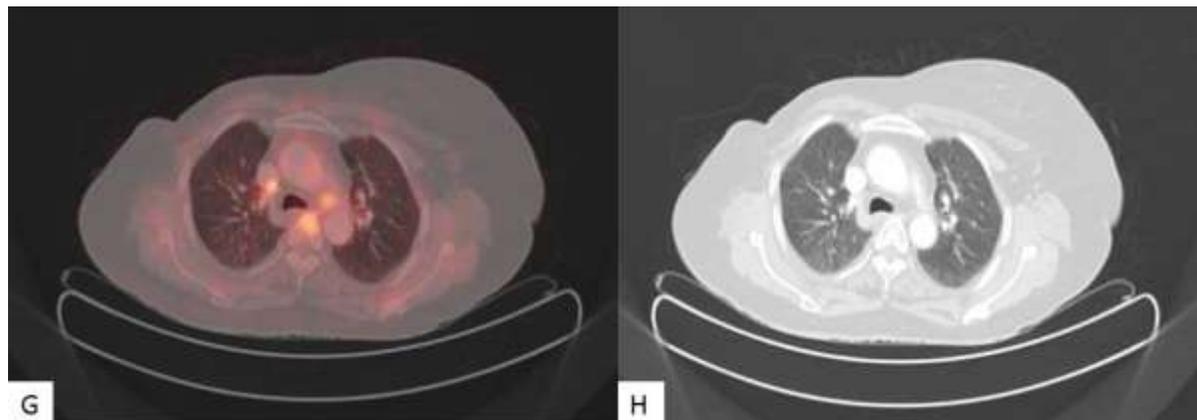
Second FDG PET-CT scan done showed disappearance of the focal uptake in lung (G) and no lesion on CT image (H)
